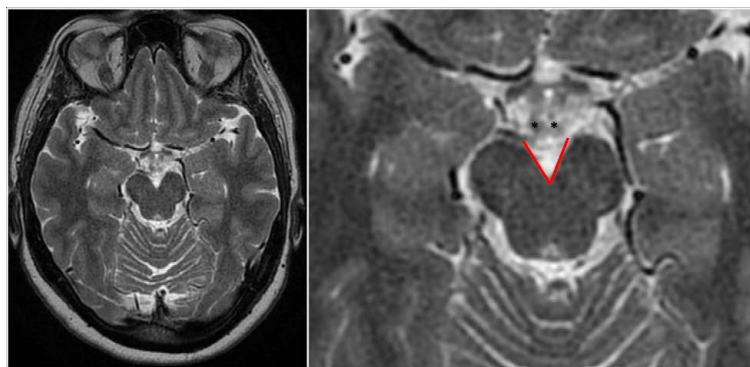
The interpeduncular angle is the angle formed between the posterior half of the cerebral peduncles, measured on an axial T2-weighted MR image at the level of the mammary bodies (*) or the slice immediately below, whichever yields a lesser value.
